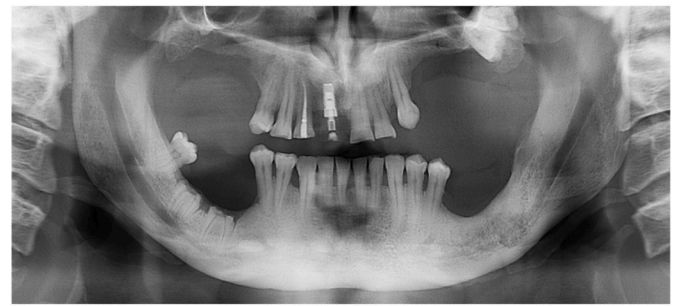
Panoramic X-ray 18 month after surgery.
